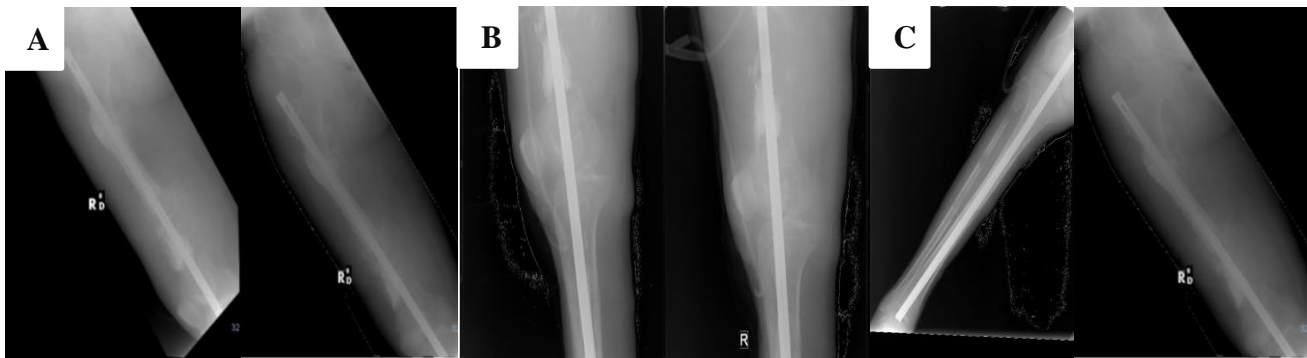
Cemented intramedullary nailing of right femur extended to distal tibia following wide excision of the tumor. (A): femur X-ray AP/Lateral view, (B): knee X-ray AP/Lateral view, (C); cruris X-ray AP/Lateral view.
